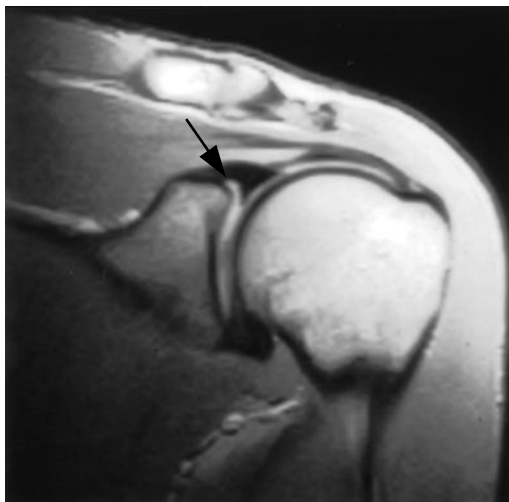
MRI appearance of a detached superior glenoid labrum (*arrow*). The linear high-intensity area between the superior labrum and the glenoid rim on an oblique coronal T2*-weighted image that passed through the center of the glenoid fossa
